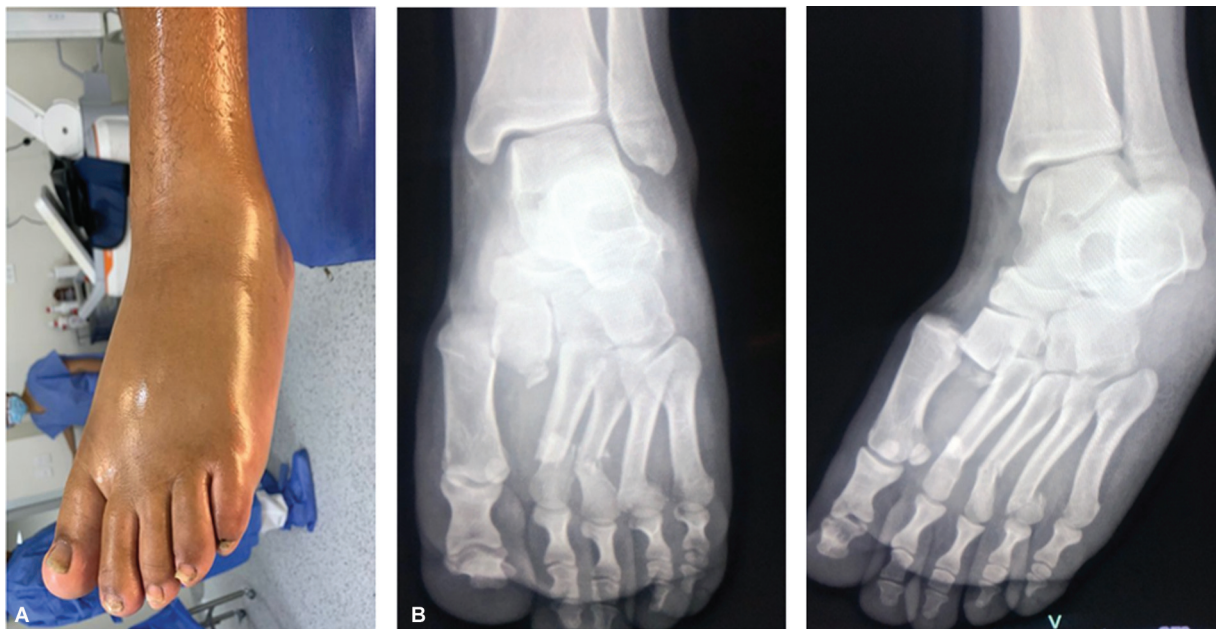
(A) Soft tissue involvement, shiny and tense skin. (B) Anteroposterior and oblique radiographs of the left foot upon hospital admission.
